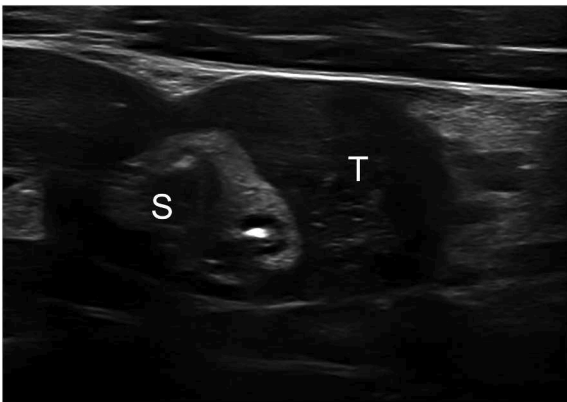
Ultrasound of patient 3 (S: Stomach, T: Tumor).
